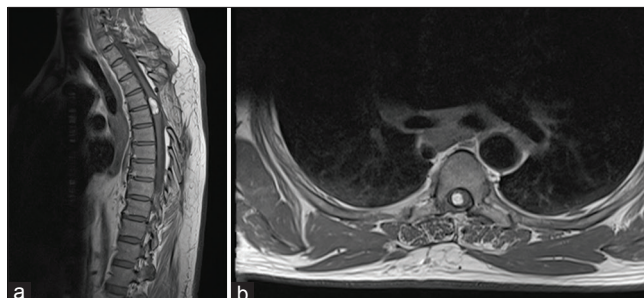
Postoperative T1-weighted gadolinium-enhanced magnetic resonance images showing significantly reduced size of T4/5 intramedullary spinal cord lipoma in the sagittal (a) and transverse planes (b)
